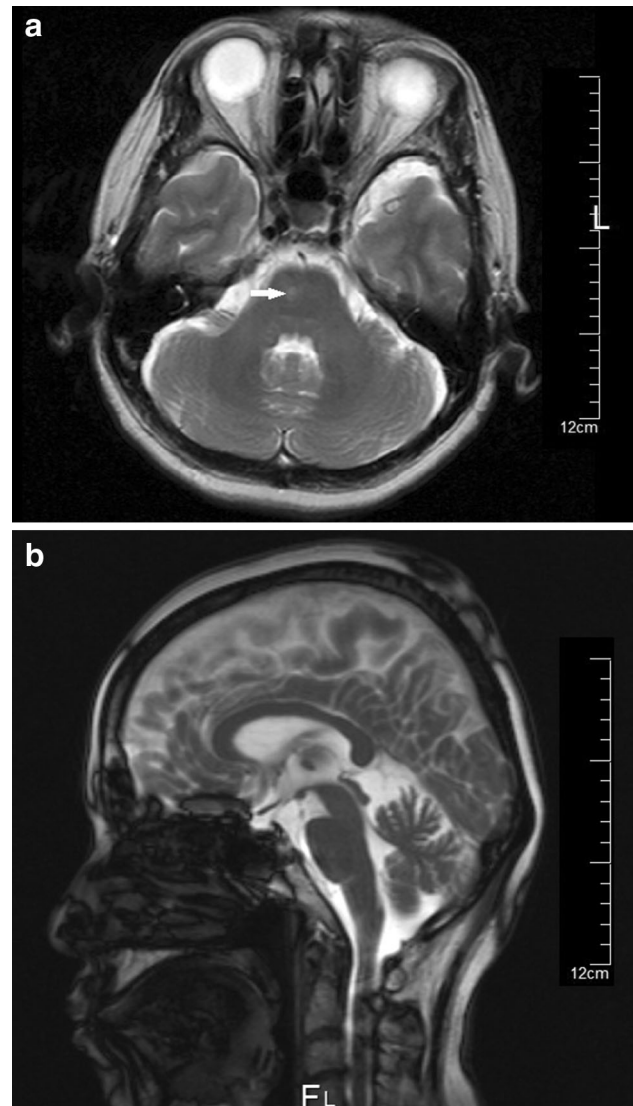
a A T₂-weighted MRI image on POD 13 shows a localized high-intensity spot in the pons (*white arrow*). b MRI image on POD 13
